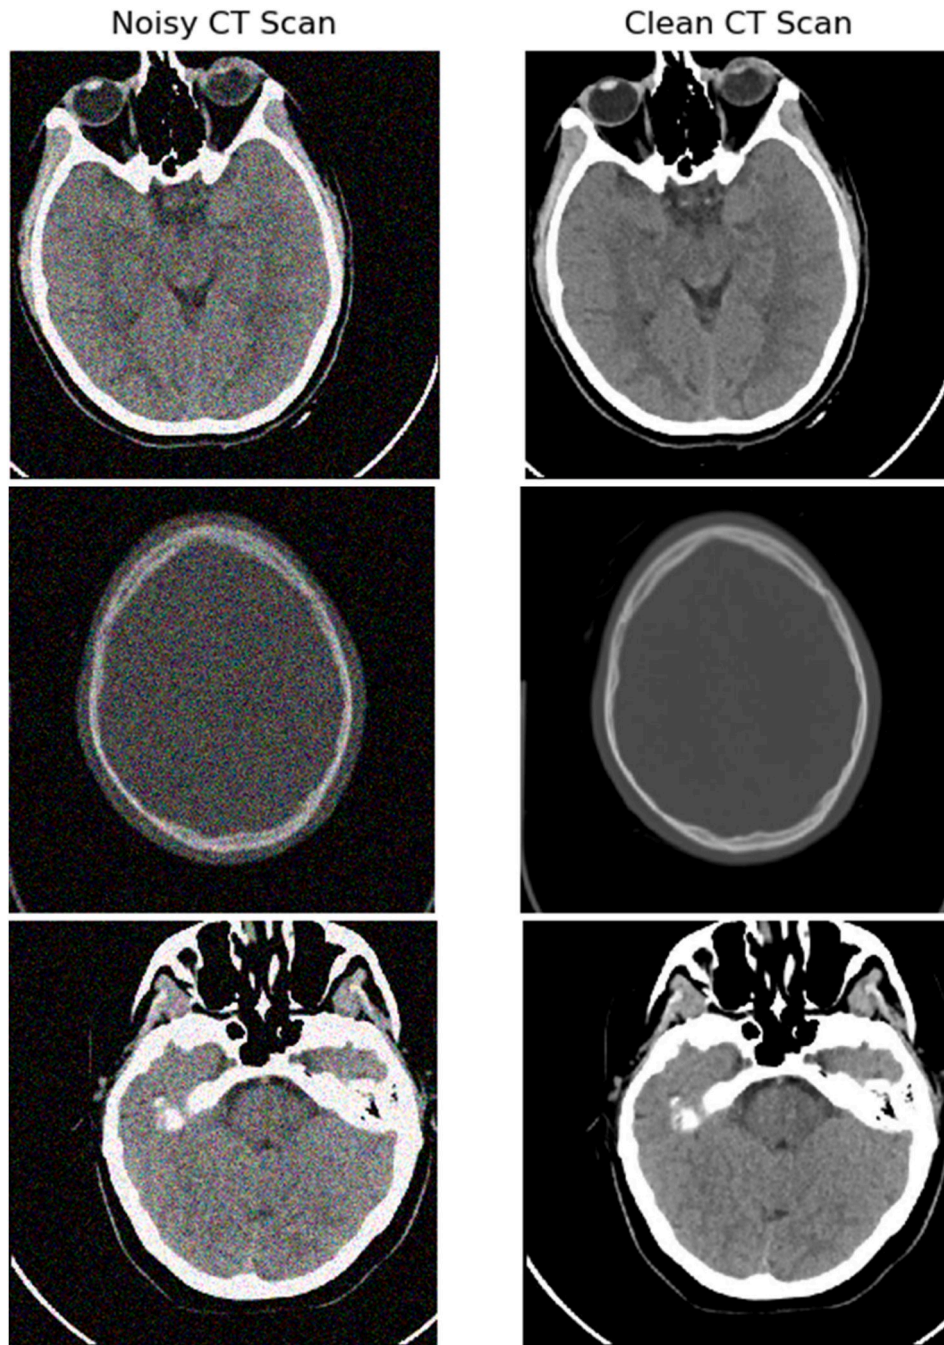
Clean and noisy CT images.
